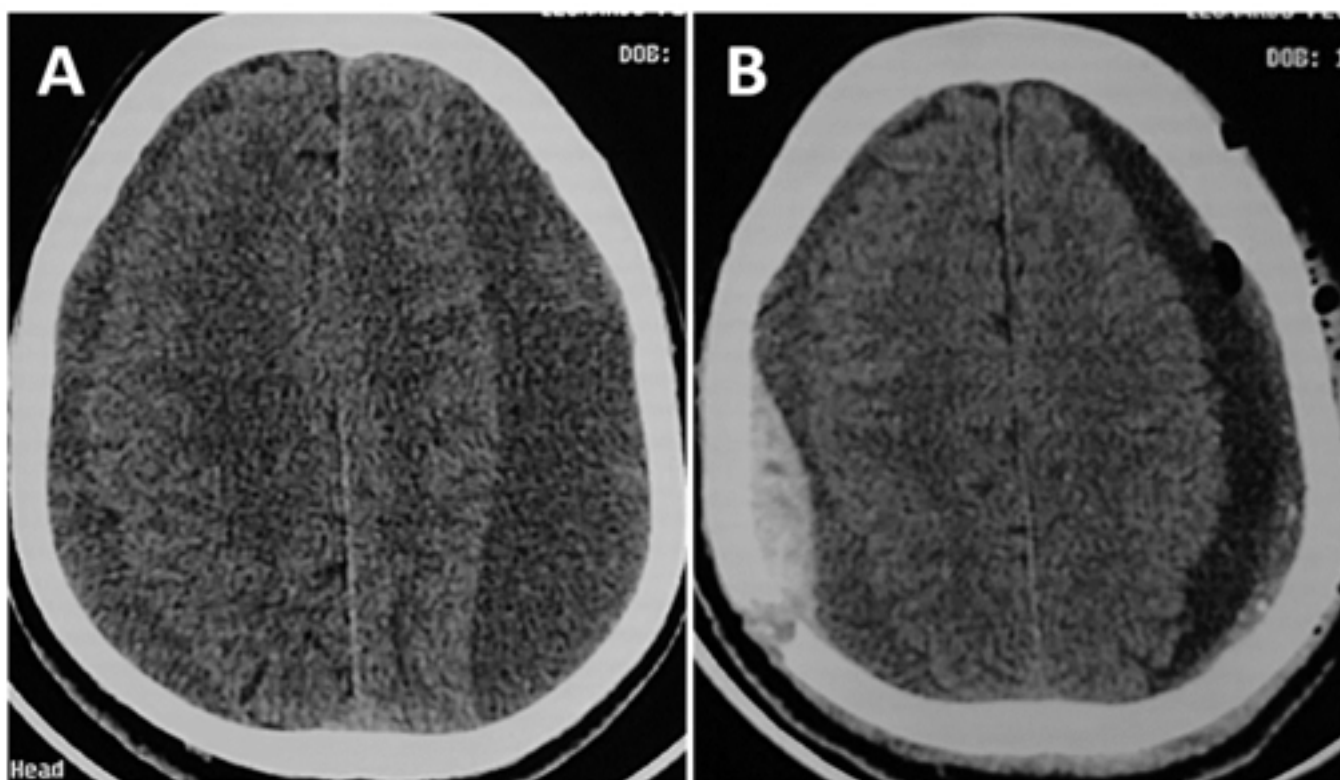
A. Preoperative computed tomography scans demonstrating bilateral chronic subdural hematoma. B. Post-operative computed tomography scans showing right parietal epidural hematoma.
